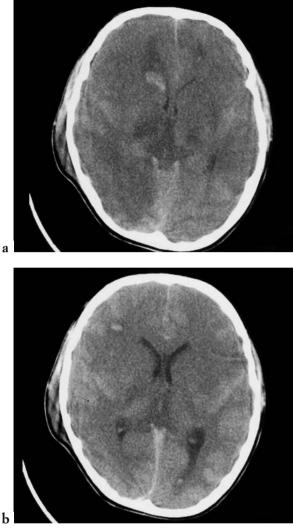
Posttraumatic cerebral oedema. The CT reveals posttraumatic cerebral oedema is observed associated with diffuse hypodensity of the white matter and obliteration of the Sylvian and perimesencephalic cisterns, a reduction in the size of the ventricular system and small intraparenchymal right haemorrhages in the right frontal region.
